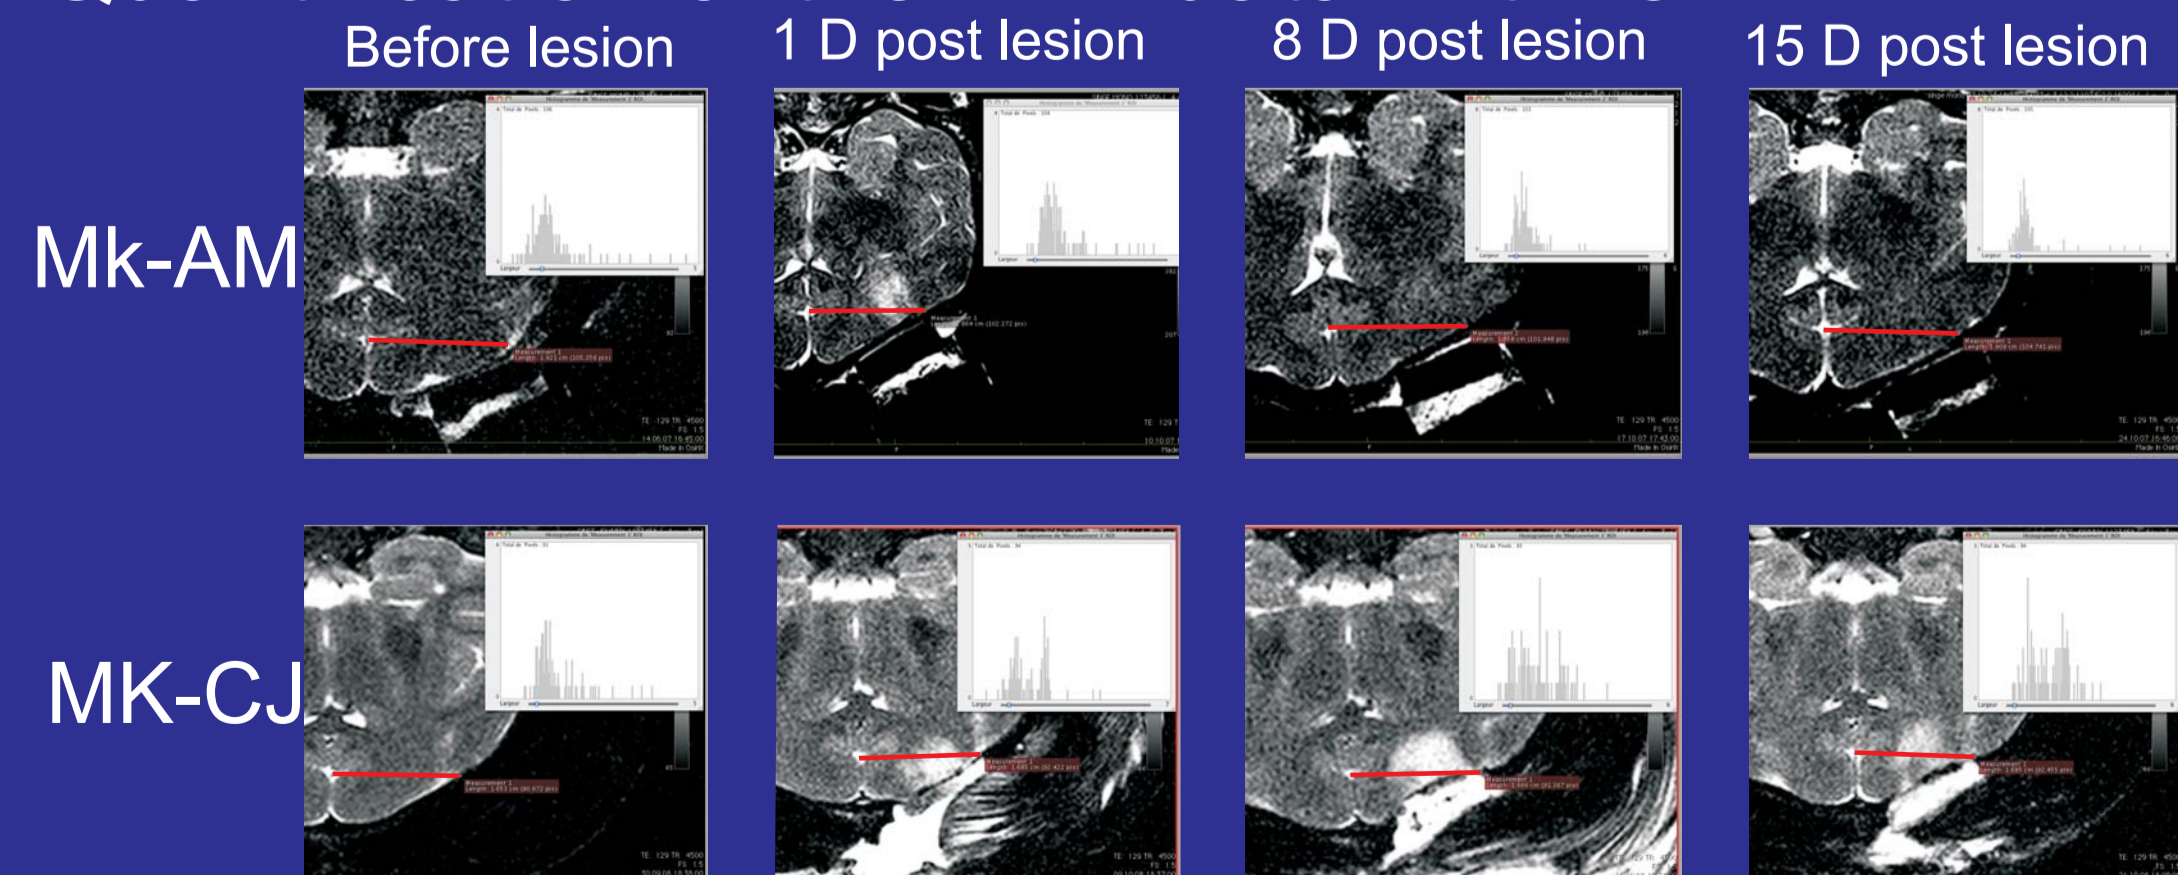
Quantification of Cortical lesion made by analysis of the distribution of the pixels intensity along a virtual line crossing the lesion and similarly located in the different MRI sessions.
